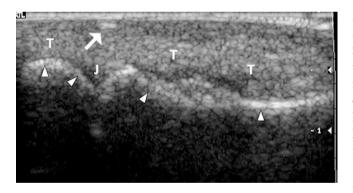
Foreign body on ultrasound. Ultrasound image along longitudinal axis of a digit shows a small hyperechoic line (arrow) representing a small 12 mm foreign body. Thicker hyperechoic lines (arrowheads) represent the bony cortex, which obscures the underlying medullary cavity. T tendon, J joint space
